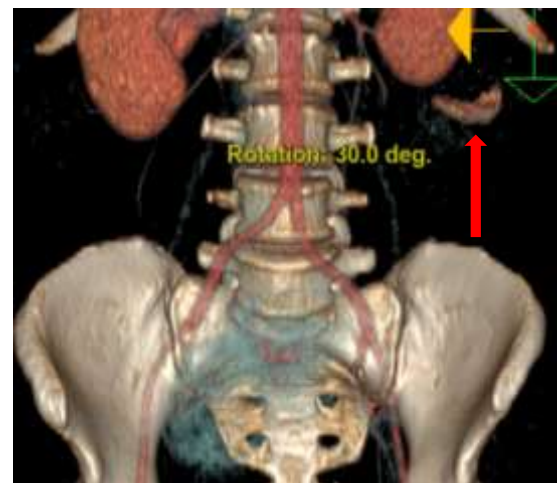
Digitally created CT imaging showing suspected foreign body (red arrow).
